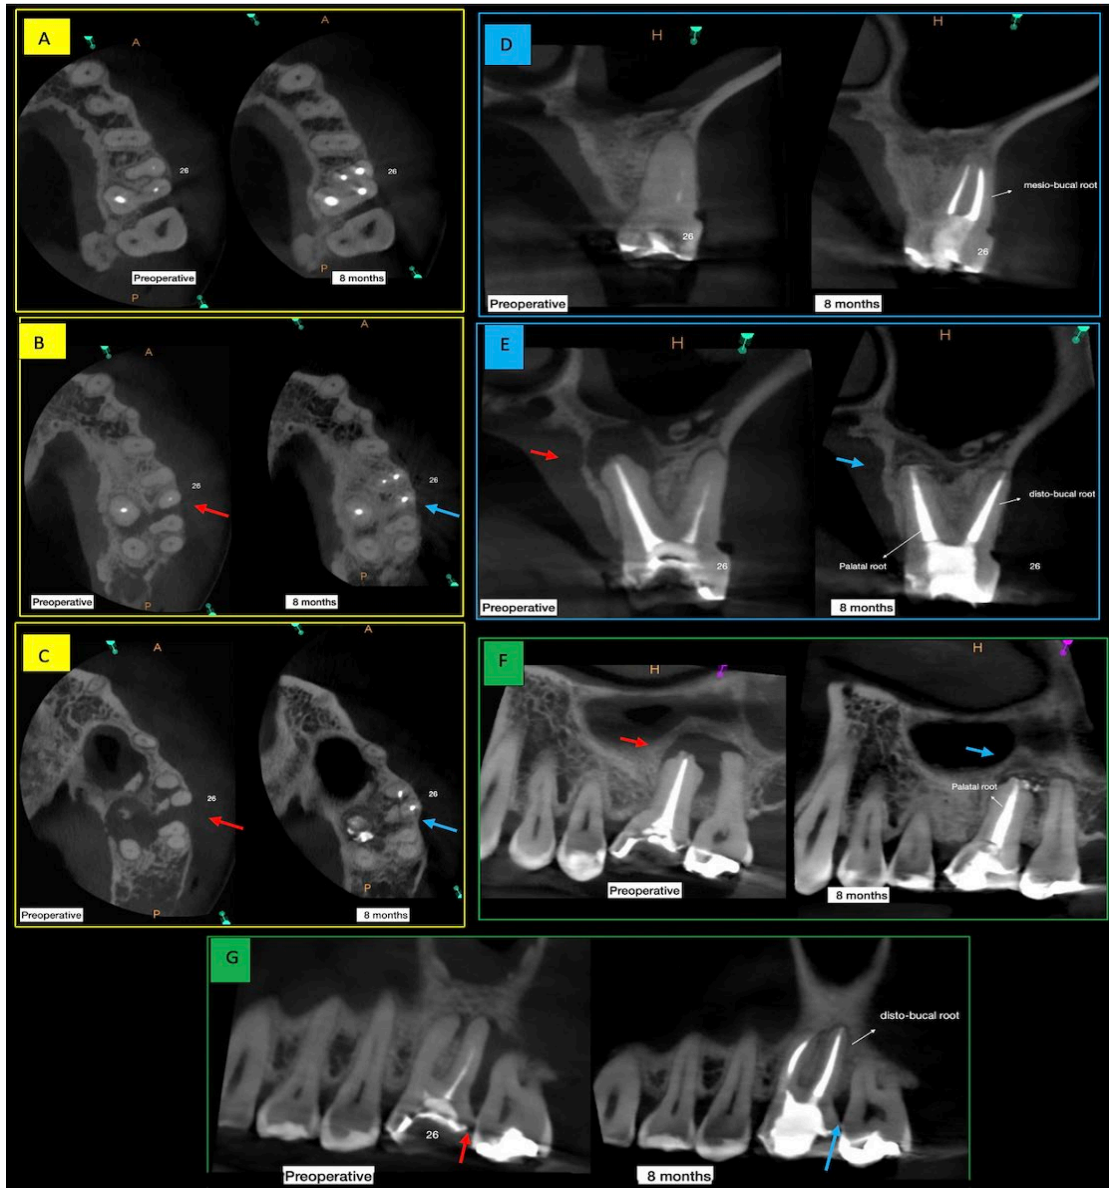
Comparative CBCT images of case 1 (preoperative and after 8 months), A, B, C) Axial sections at cervical, middle and apical thirds, respectively; D, E) Sagittal images; F, G) Coronal images; The red arrows indicate the osteolytic lesion (preoperative) and the blue arrows the bone recovery (postoperative, 8 months after)
